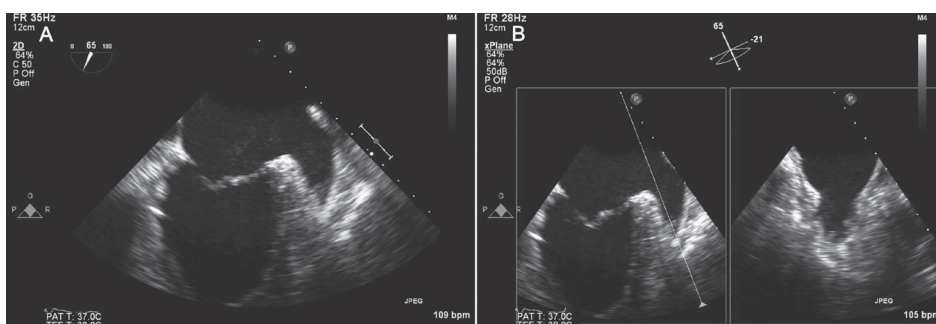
Left atrial appendage thrombus. A. iRotate of 65° during transesophageal echocardiography showing a suspected thrombus in the left atrial appendage. B. xPlane with lateral tilt of -21° showing in the secondary image clear pectinate muscles rather than organized thrombus.
